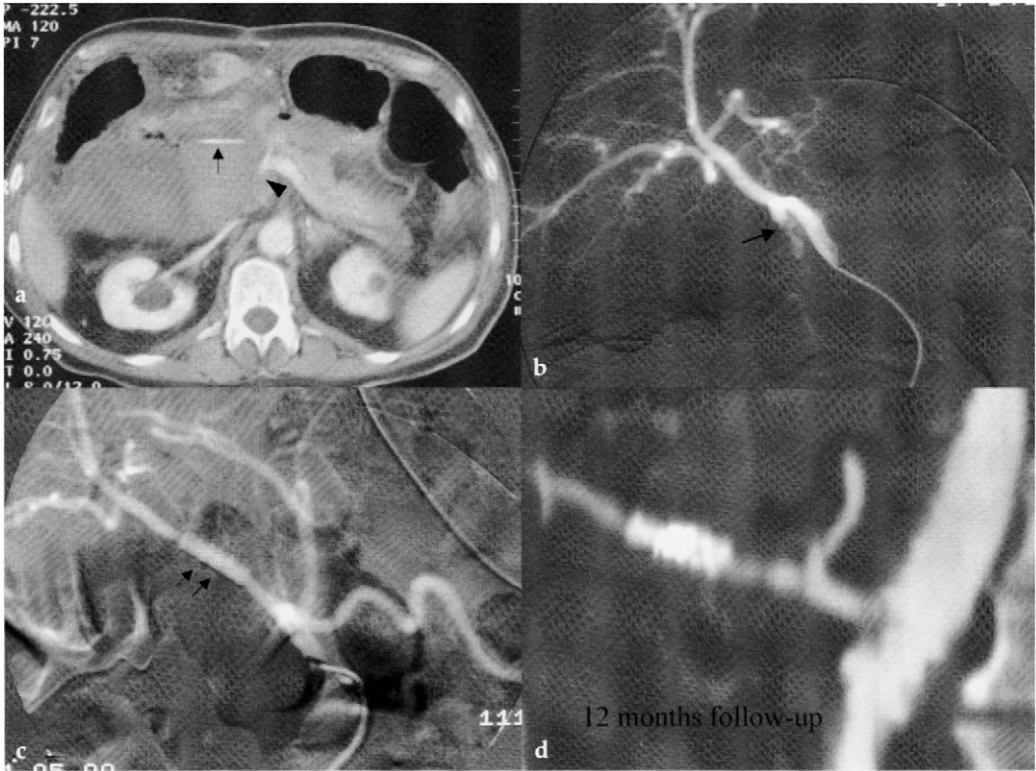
Splanchnic artery bleeding after pancreatoduodenectomy (two cases). Axial CT scan, carried out in the venous contrastographic phase, highlights a voluminous subhepatic hematoma with intraperitoneal spread of contrast medium resulting in a contrast-blood level (arrow). The spleno-portal confluence (arrowhead) is compressed by the huge hematoma.
